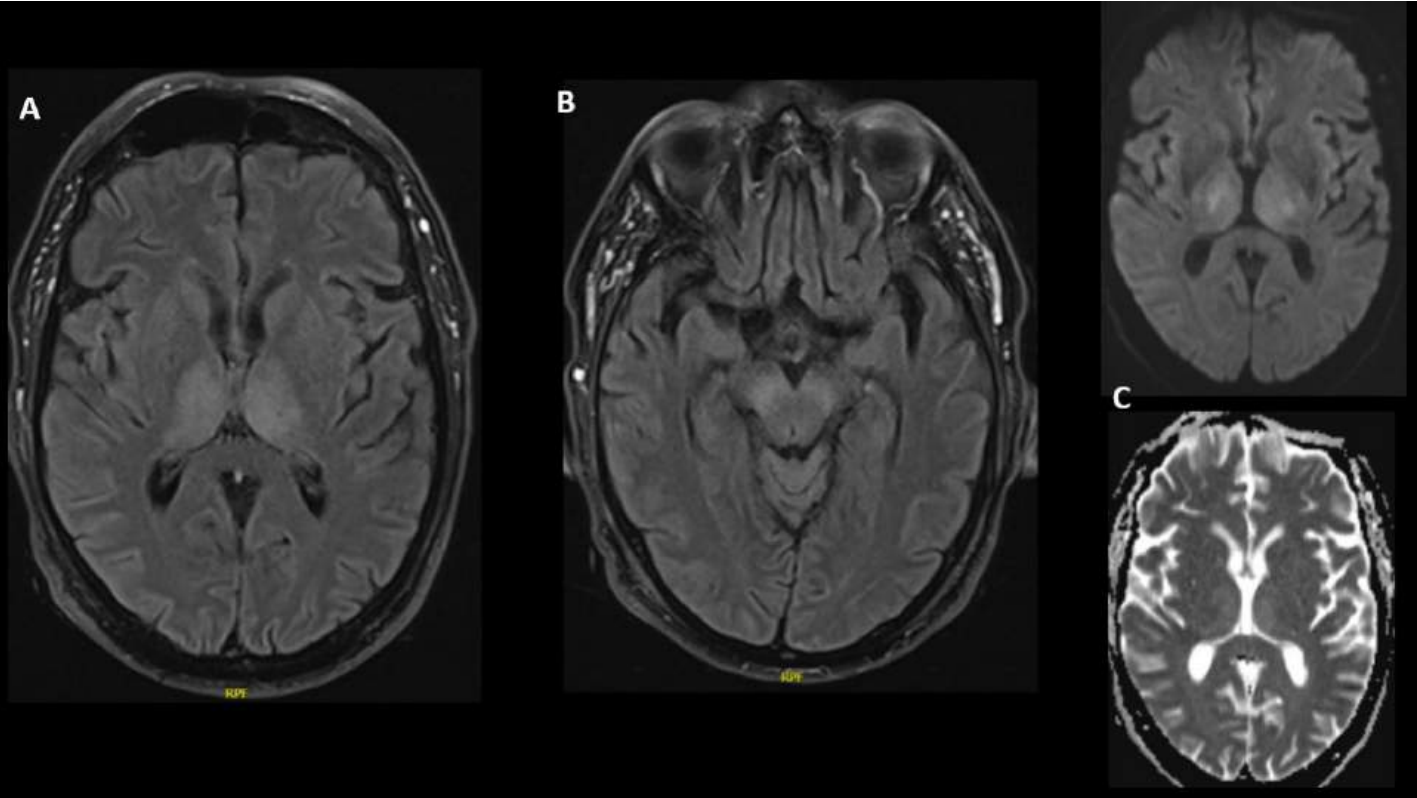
Figuur 1 MRI scan
